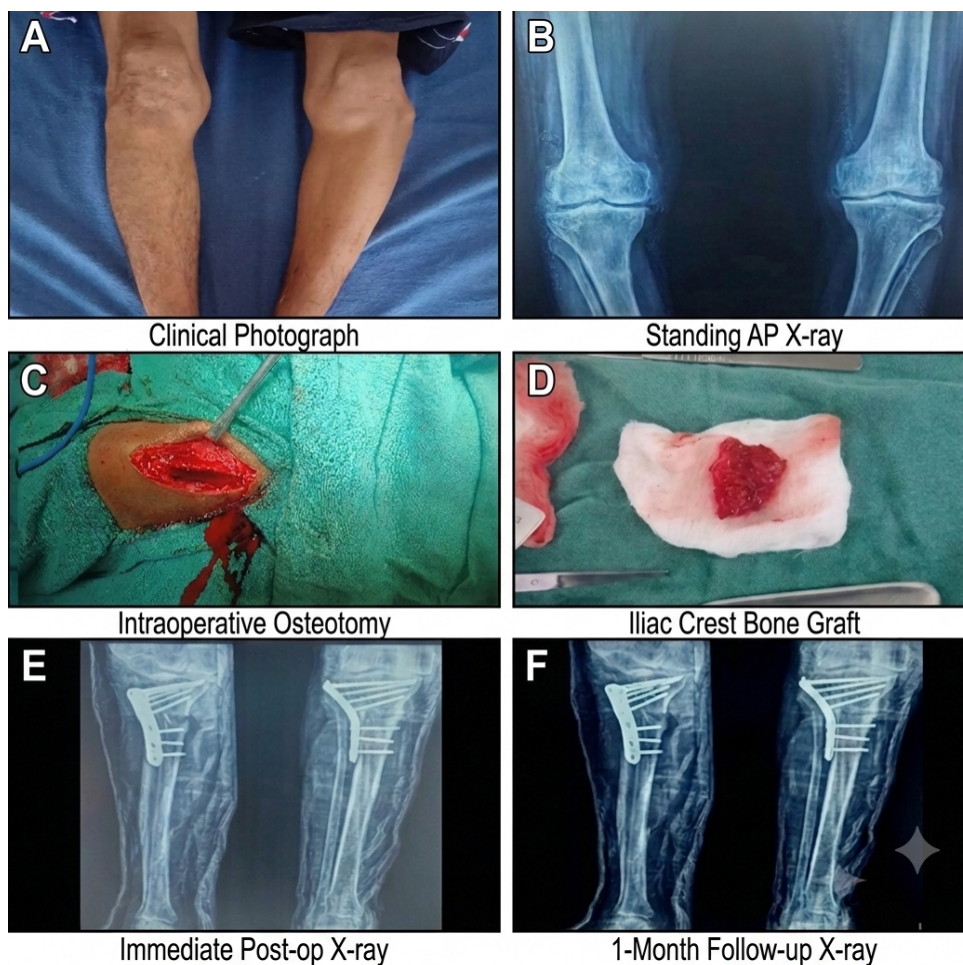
Chronological clinical and radiological outcomes of high tibial osteotomy. (A) Preoperative clinical photograph showing genu varum deformity. (B) Preoperative standing AP radiograph demonstrating medial compartment narrowing. (C) Intraoperative photograph of the opening wedge proximal tibial osteotomy. (D) Harvested autologous iliac crest bone graft. (E) Immediate postoperative AP radiograph showing internal fixation and mechanical axis correction. (F) One-month follow-up AP radiograph confirming maintained alignment and graft consolidation.
